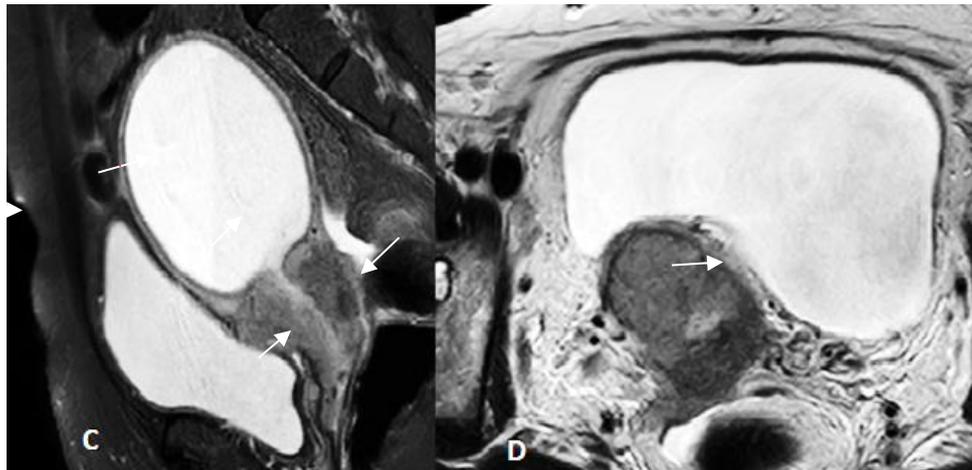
(C) (D) In the same patient MRI-pelvis T2 sagittal and axial image shows bulky cervix with asymmetrical diffuse long segment anterior and posterior lip thickening, causing cervical canal stenosis with endometrial collection (dashed arrow). The fat plane between the urinary bladder posterior wall and anterior wall of the rectum appears preserved. On HPE the lesion was identified as SCC of the cervix.
